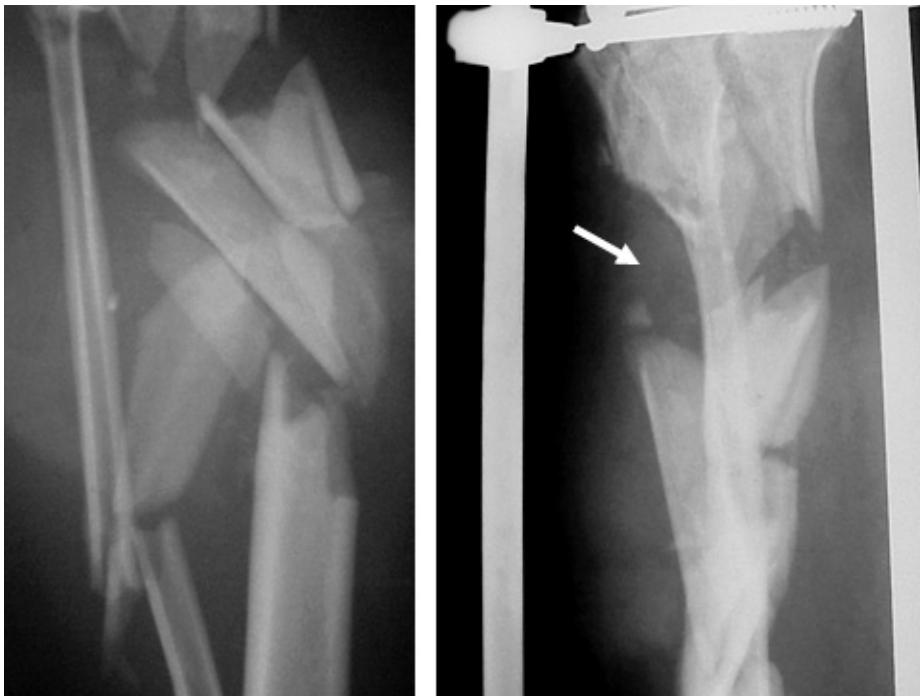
(a,b) X-rays of right leg of the second patient showed severe comminuted fracture of tibia and fibula. After external fixation, there was some bony defect at tibial crest. (arrow)
